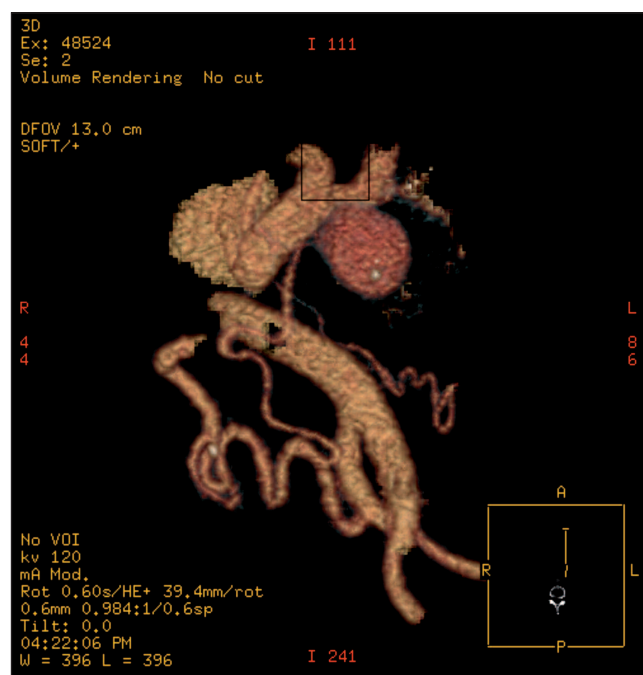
Aortic angio-CT scan where 39-cm-in-diameter pancreatic pseudoaneurysm is verified, attached to a branch of the gastroduodenal artery.
